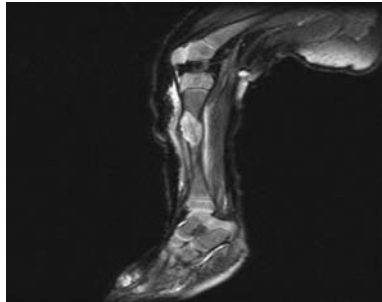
Sagittal T1 contrast enhanced MRI right tibia, showing a well defined mildly expansile eccentric cortical osteolytic enhancing lesion at right proximal tibial diaphysis, mild overlying periostitis and soft tissue reaction, and narrow zone of transition.
